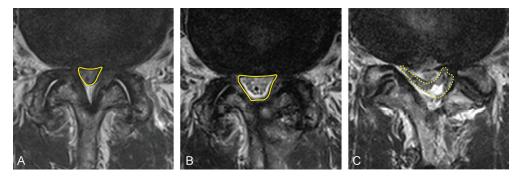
Measuring the cross-sectional area (CSA) of the dura sac and epidural hematoma on magnetic resonance imaging. (A and B) Pre- and postoperative dura sac CSA was measured (yellow line). (C) The CSA of the postoperative epidural hematoma was measured (yellow dotted line).
